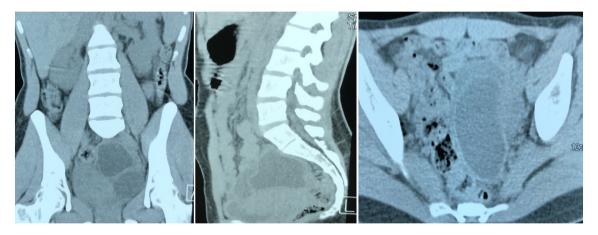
A CT scan of the abdomen and pelvis showing bi-vesicular lesions with a clear cavity within the left ovary.
